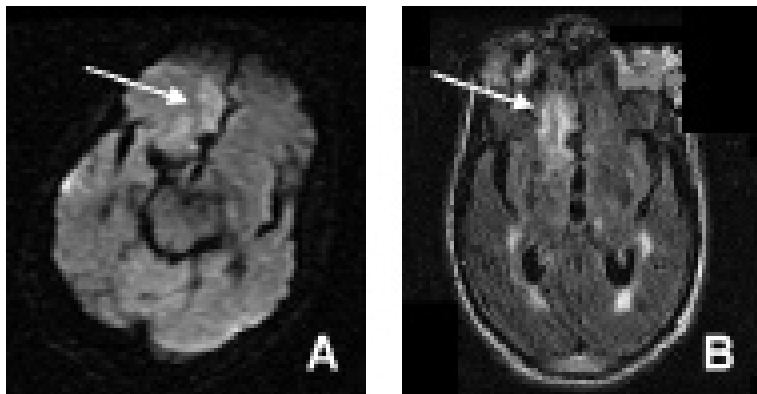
Axial magnetic resonance imaging showing area of acute on chronic infarction appearing as high signal on diffusion weighted imaging (A) as fluid attenuated inversion recovery image (B) indicated by arrows.
